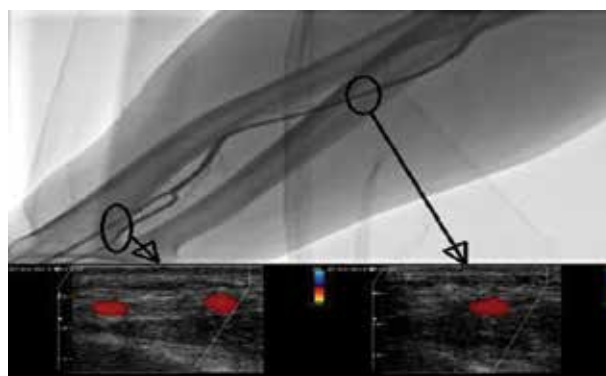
High origin of the superficial ulnar artery within the forearm. Angiographic image (upper panel) and corresponding transverse sections in ultrasonography (lower panel)
